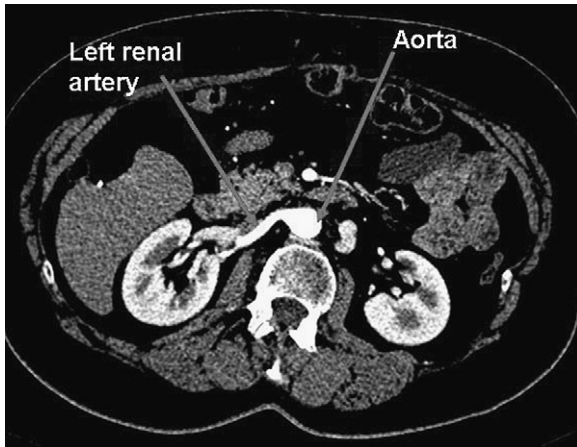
A computed tomography (CT) slice (Siemens SOMA-TOM Sensation Cardiac 64) of the abdominal region from a healthy volunteer with the aorta and left renal artery highlighted.
